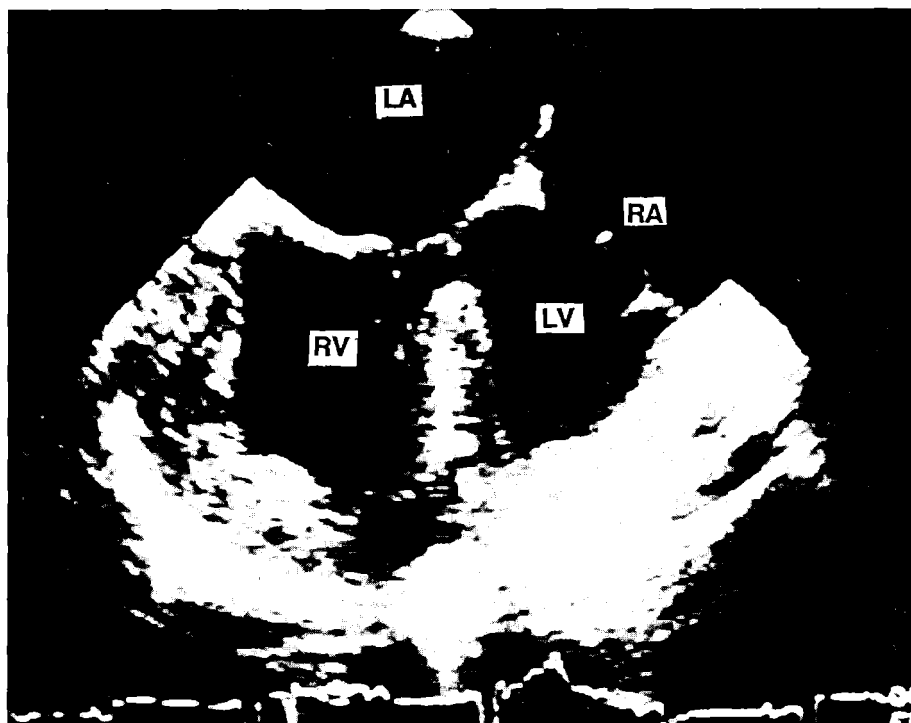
Transesophageal four chamber view in a patient with dextrocardia, situs inversus and congenitally corrected transposition. The atrial septum is malaligned with respect to the ventricular septum. The reversed offsetting of the two AV valves is clearly seen.
